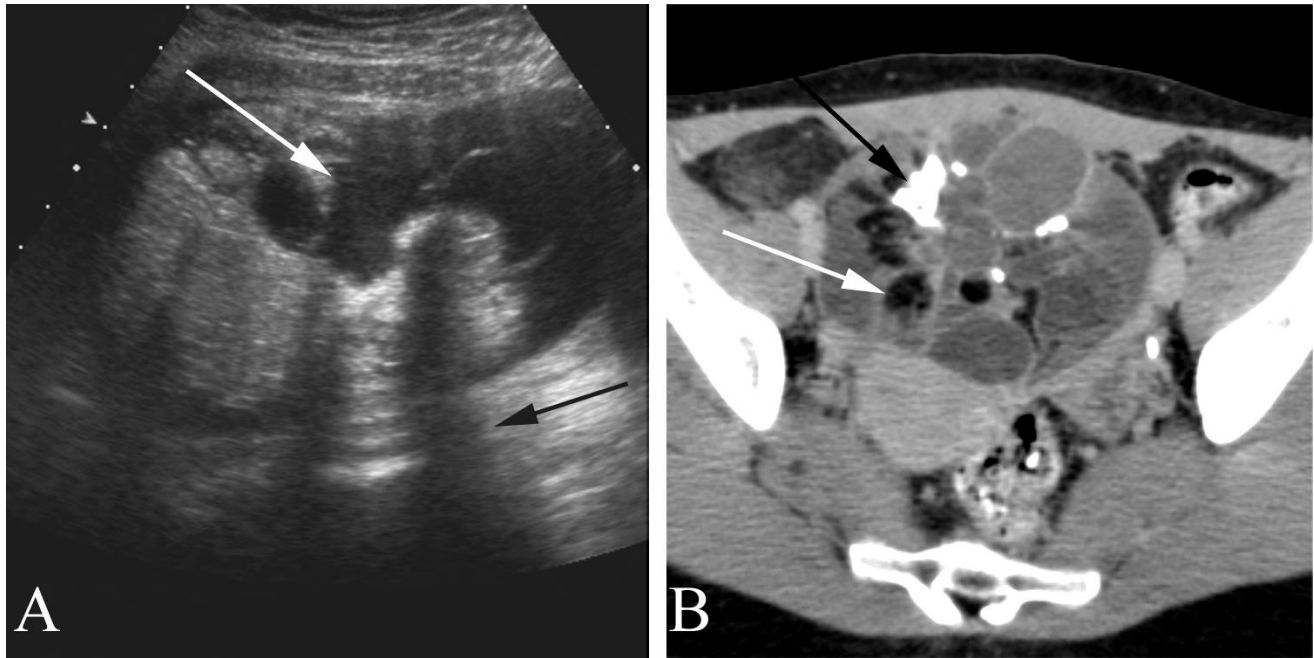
Pelvic (ovarian) dermoid in a 17 year old with a painless pelvic mass. A. Transvaginal ultrasound shows a cystic component (white arrow) as well as an intensely echogenic region which casts a shadow (black arrow). B. CT scan shows both calcified (black arrow) and fatty (white arrow) components in a large predominantly hypodense (cystic) lesion. Surgical resection was performed, yielding an ovarian dermoid.
